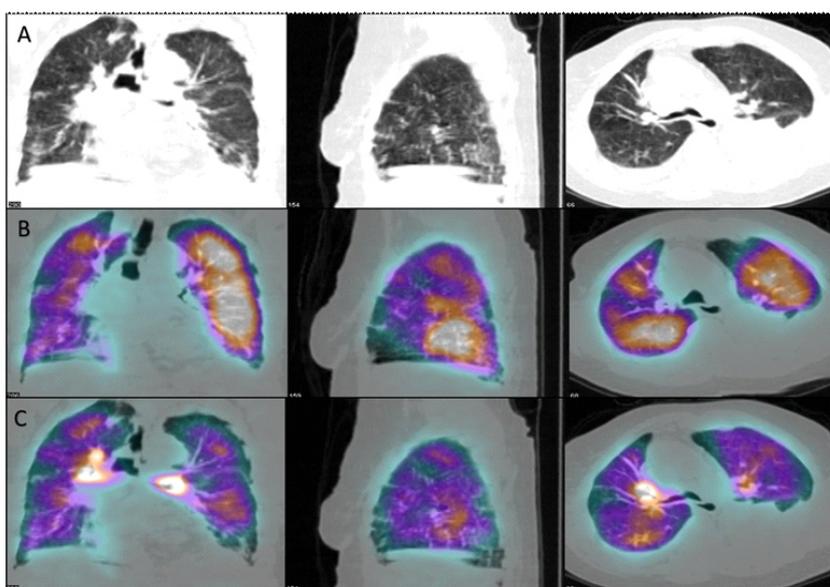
Coronal, sagittal, and transaxial slices of LdCT (line A), Q SPECT/CT (line B), and V SPECT (line C) images in a patient with chronic obstructive pulmonary disease. LdCT shows some non-specific parenchymal abnormalities which not corresponded to perfusion defects. Therefore the patient has non-diagnostic results with Q SPECT/CT. However, ventilation defects are thoroughly matched with perfusion abnormality, and PTE was excluded in this patient.
